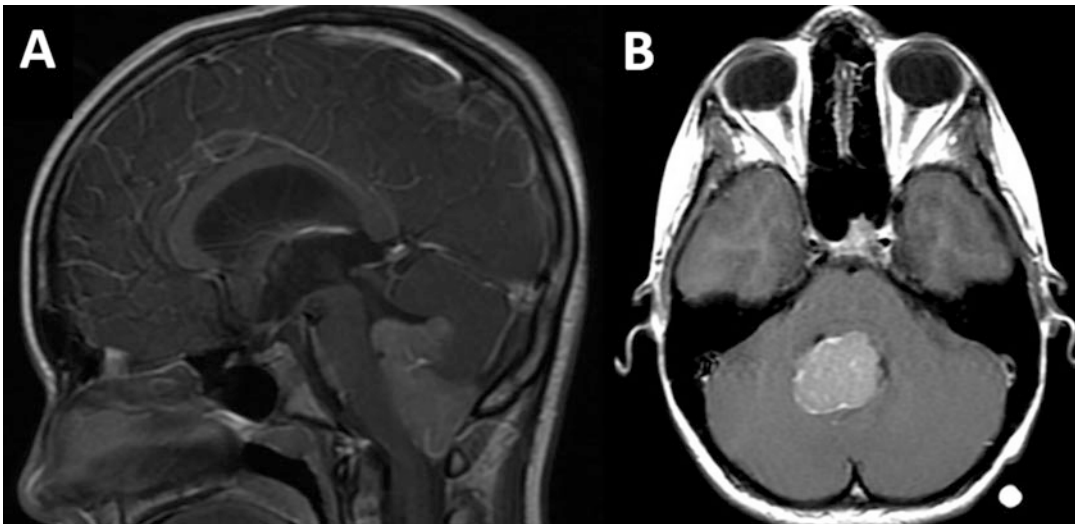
(a) Brain MRI T1WI+C sagittal sequence showing a fourth ventricle medulloblastoma. Ten-year-old boy that presented with a several-month history of emesis
